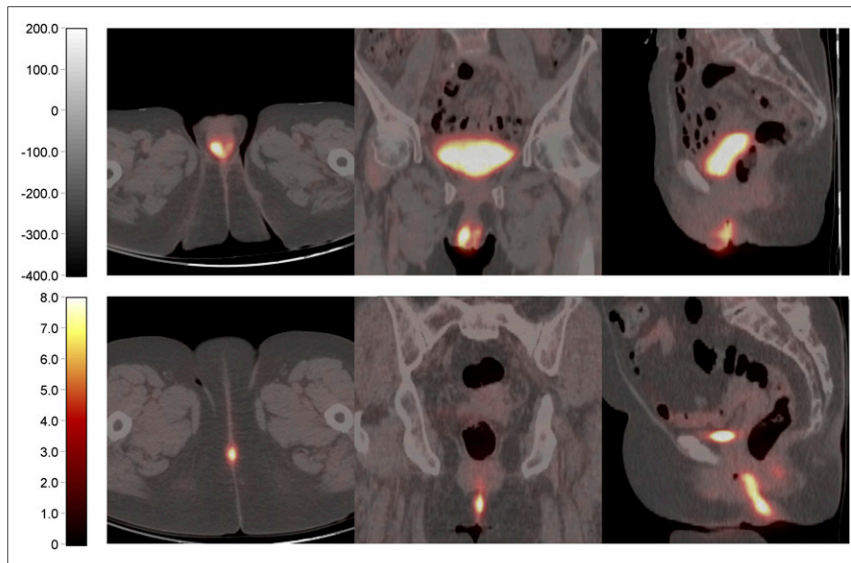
From left to right, transverse, coronal, and sagittal ^{18}F -FDG PET/CT images of 2 women with vulvar carcinoma. (Top) An 81-y-old woman who had anterior midline 4-cm-diameter tumor with heterogeneous ^{18}F -FDG uptake and relatively high Moran's I (0.0924). Inguinal lymph node recurrence and death occurred 4 and 16 mo after surgery, respectively. (Bottom) A 74-y-old woman who had posterior midline 3-cm-diameter tumor with homogeneous ^{18}F -FDG uptake and low Moran I (0.0213). At time of last follow-up, patient was alive and without recurrence.
